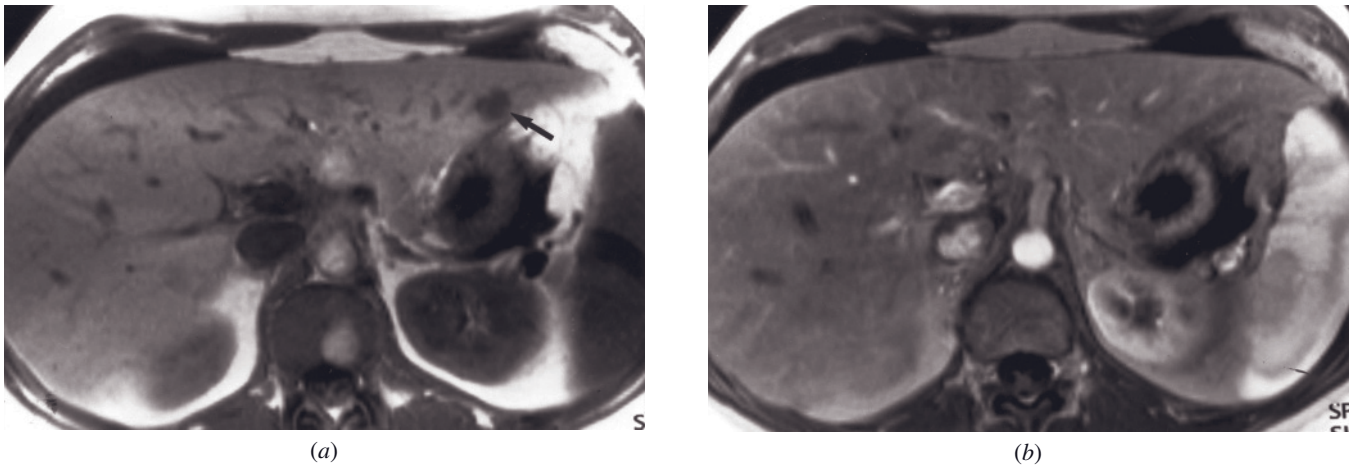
Near-isovascular liver metastases. SGE (a) and hepatic arterial phase gadolinium-enhanced SGE (b) images. In this patient with liver metastases who is at 9 months after initiation of chemotherapy, liver metastases are clearly shown on noncontrast T1-weighted images (arrow, a) but poorly seen after gadolinium administration. This enhancement pattern, termed near-isovascular, is most commonly observed in liver metastases in a subacute phase of response to chemotherapy.
